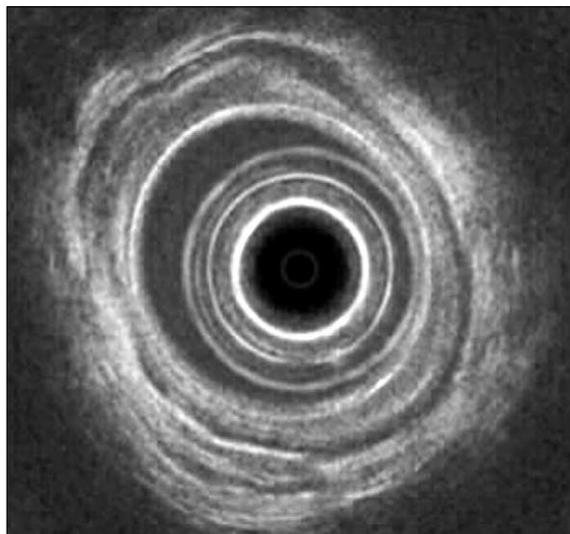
Early cancer detected by endoscopic ultrasound in patient with high-grade dysplasia
